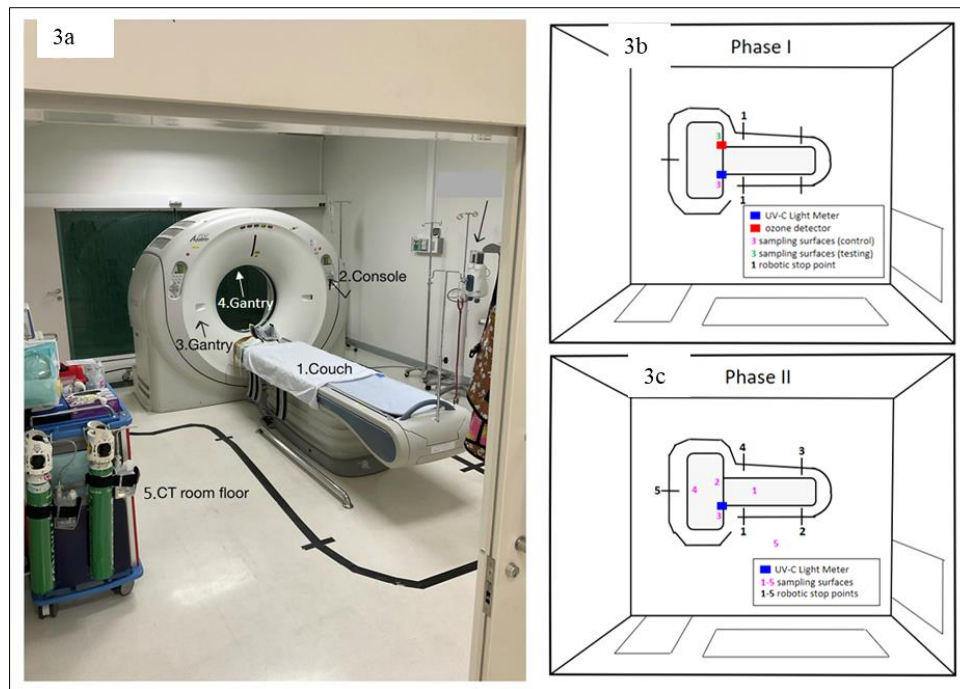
Experimental setup. (a) Layout of the CT room; (b) Phase I: Control surface (pink) and test surface (green) on the CT console, with UV-C light meter (blue) and ozone detector (red) placed at the test surfaces. Robot irradiation at 1 m distance for 2, 4, 6, and 8 minutes; (c) Phase II: Five sampling surfaces with five robotic stop points, each irradiated for 4 minutes, and UV-C light meter (blue) at CT console surface (3) for intensity measurements.
